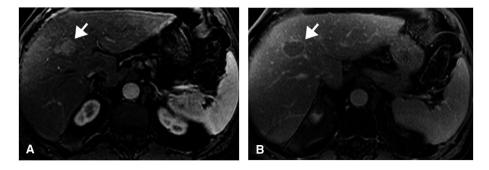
A 57-year-old man with HCC in the background of chronic hepatitis C–related cirrhosis. Axial postcontrast T1-weighted MRIs in the arterial (A) and the delayed phase (B) demonstrate a well-circumscribed oval observation measuring 2.5 cm in maximal dimension. This lesion exhibits homogeneous hyperenhancement in the arterial phase (arrow) with washout and enhancing capsule in the delayed phase (arrow) consistent with LR-5.
